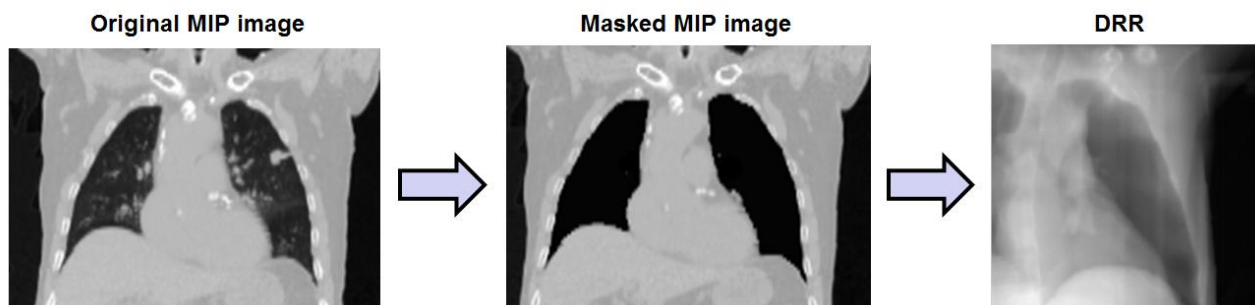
Example of digital reconstructed radiograph obtained by projecting the masked MIP image, which is computed by segmenting the lung and tumour regions in the original MIP volume.
